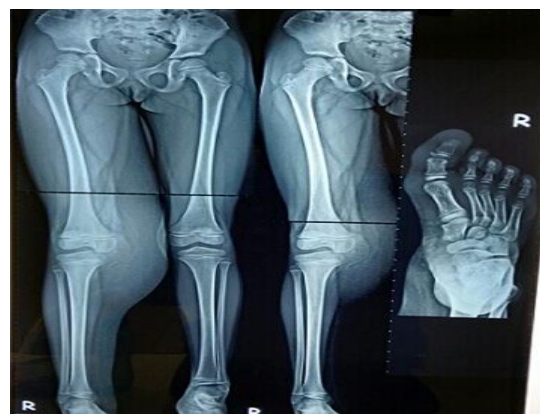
Scannogram of lower limb with X-ray right foot AP view.
